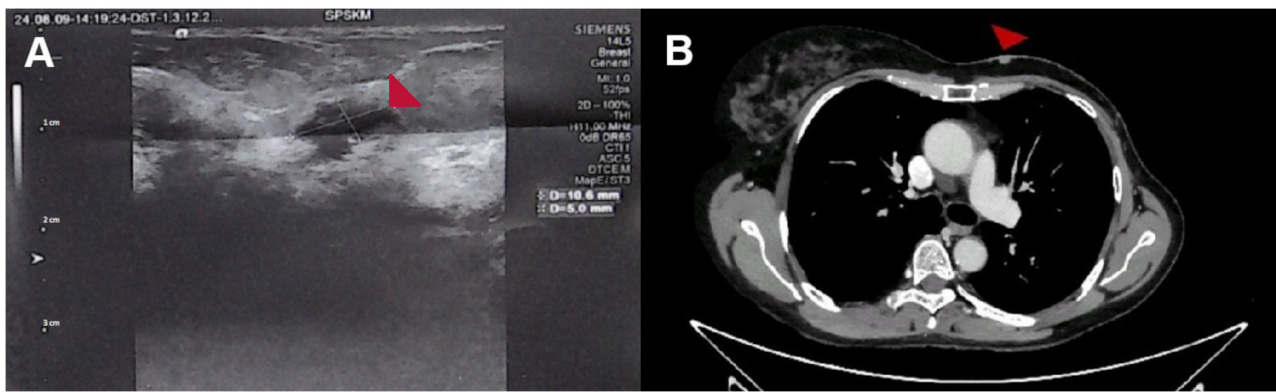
Ultrasound imaging and computed tomography of chest wall skin recurrence of breast cancer. Local recurrence of breast carcinoma (arrow) in the area of the mastectomy scar of the chest wall in (A) ultrasound imaging with 11 MHz linear probe and (B) contrast-enhanced computed tomography scan of the chest.
